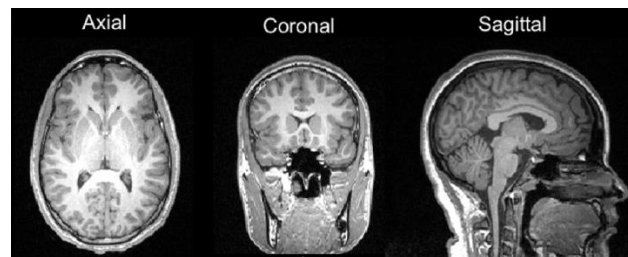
Three angles of Brain MRI
